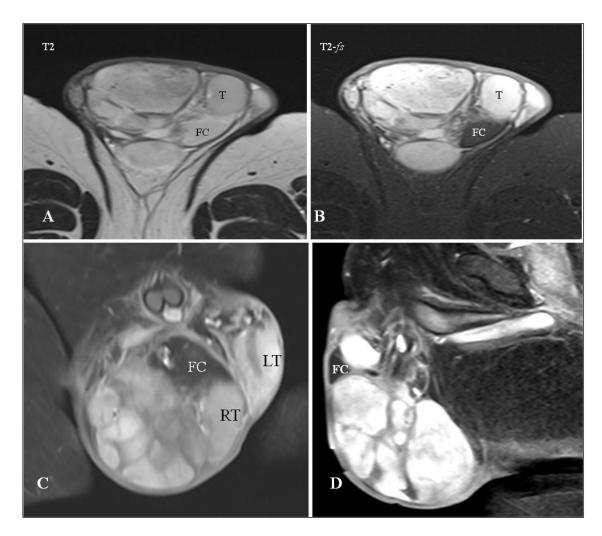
A 57-year-old patient with right spermatic cord liposarcoma. MRI (A) Axial T2 weighted & (B) axial T2 weighted fat-saturated images showing a large heterogeneously T2 hyperintense mass lesion displacing the right testis to left side and few areas of the mass lesion showing hypoattenuation on fat-saturated sequence suggestive of fat component. (C) Coronal and (D) sagittal T1 weighted fat-saturated contrast enhanced images showing heterogeneously enhancing mass in the right side of scrotum. [Note: T/RT = right testis; LT = left testis; FC = fat component].
